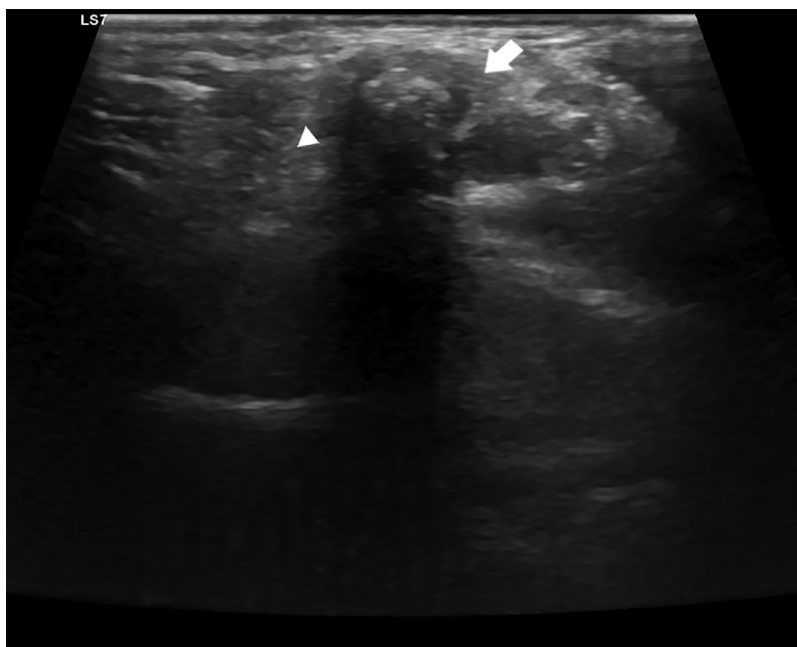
Sonogram performed on the supraclavicular region, showing a slightly hyperechogenic round formation with an hypoechoic halo (white arrow) and its acoustic shadow (white arrowhead), suggestive of bone.
